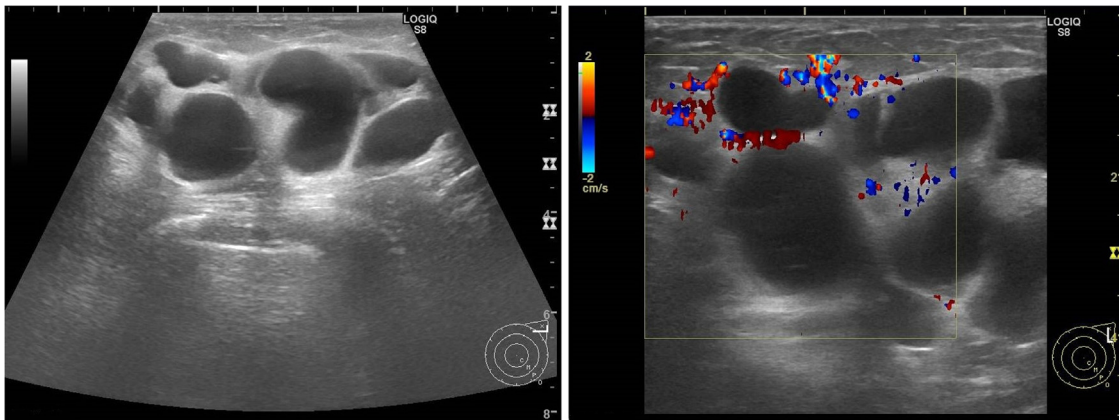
Ultrasound. Left: Lymphangioma consisting of multiple cysts and septa. Right: Color Doppler imaging indicating well flows in the walls and septa but not in the internal cysts.
